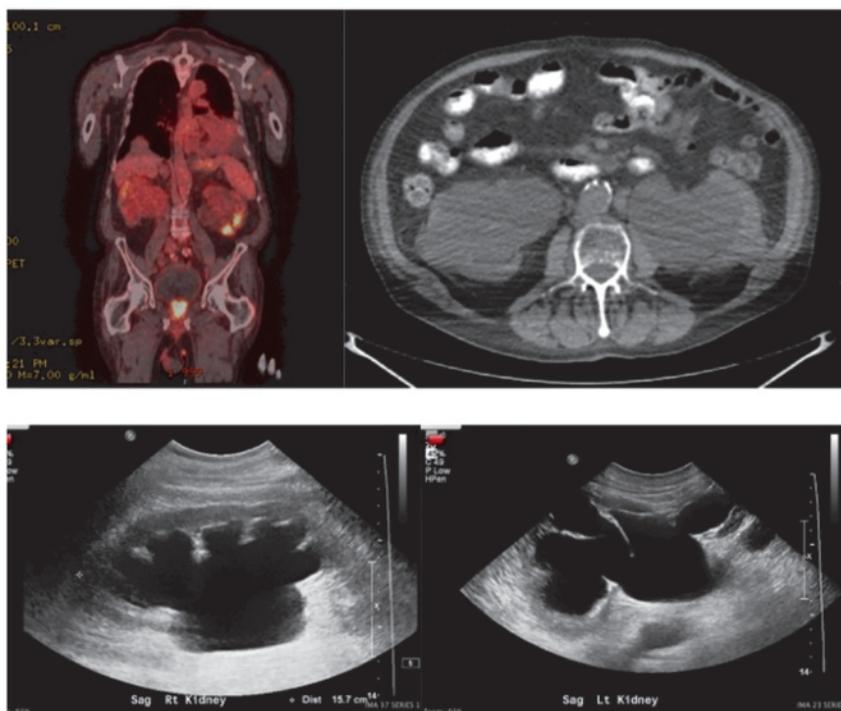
Urinary obstruction by prostatic hypertrophy. A 91 years old male with a history of submental involvement by squamous carcinoma of the skin had a PET-CT (upper row) that showed bilateral urinary obstruction from prostatic hypertrophy. This was reported by the radiologist, but not acted upon by the ordering oncologist, leading to admission three months later in renal failure. The ultrasound images (lower row) show marked bilateral hydronephrosis. The patient recovered most of his renal function after the obstruction was relieved.
